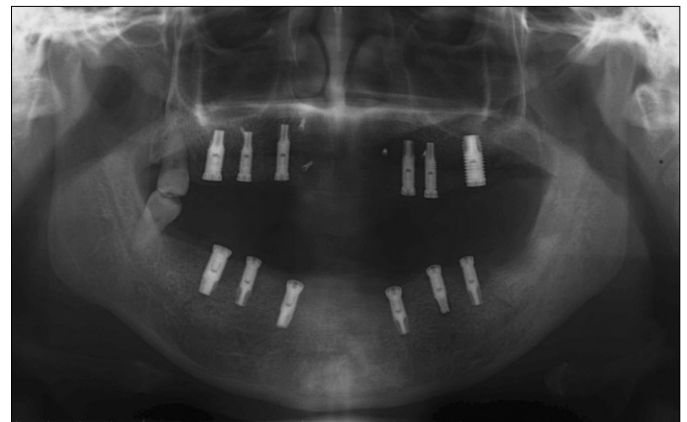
Panoramic radiograph after implant installation.
